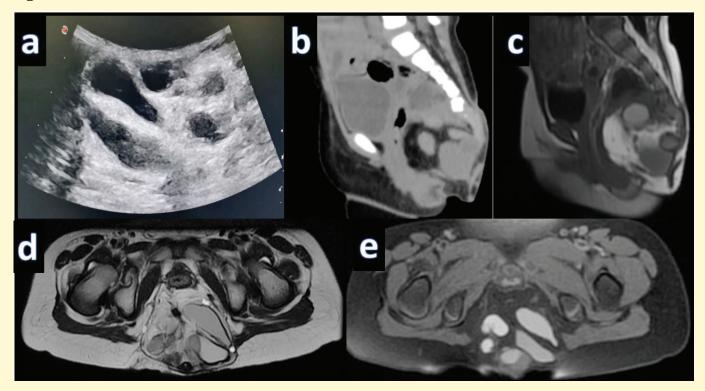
(a) ultrasound image of swelling in perineum showing well defined lesion with anechoic cystic and hyperechoic areas within (b) Midline Sagittal CT pelvis image showing well-defined lesion with cystic and fat attenuating areas noted in retro-rectal space displacing rectum anteriorly. (c)(d)(e) Midline sagittal T1W MRI pelvis, Axial T2W and Axial T1FS images of pelvis showing well-defined heterogenous lobulated mixed signal intensity predominantly cystic lesion with fat signal intense areas within noted in pelvis in presacral region, displacing rectum anteriorly, inferiorly extending into posterior perineal triangle and abutting S5 sacral segment and coccyx posteriorly.
